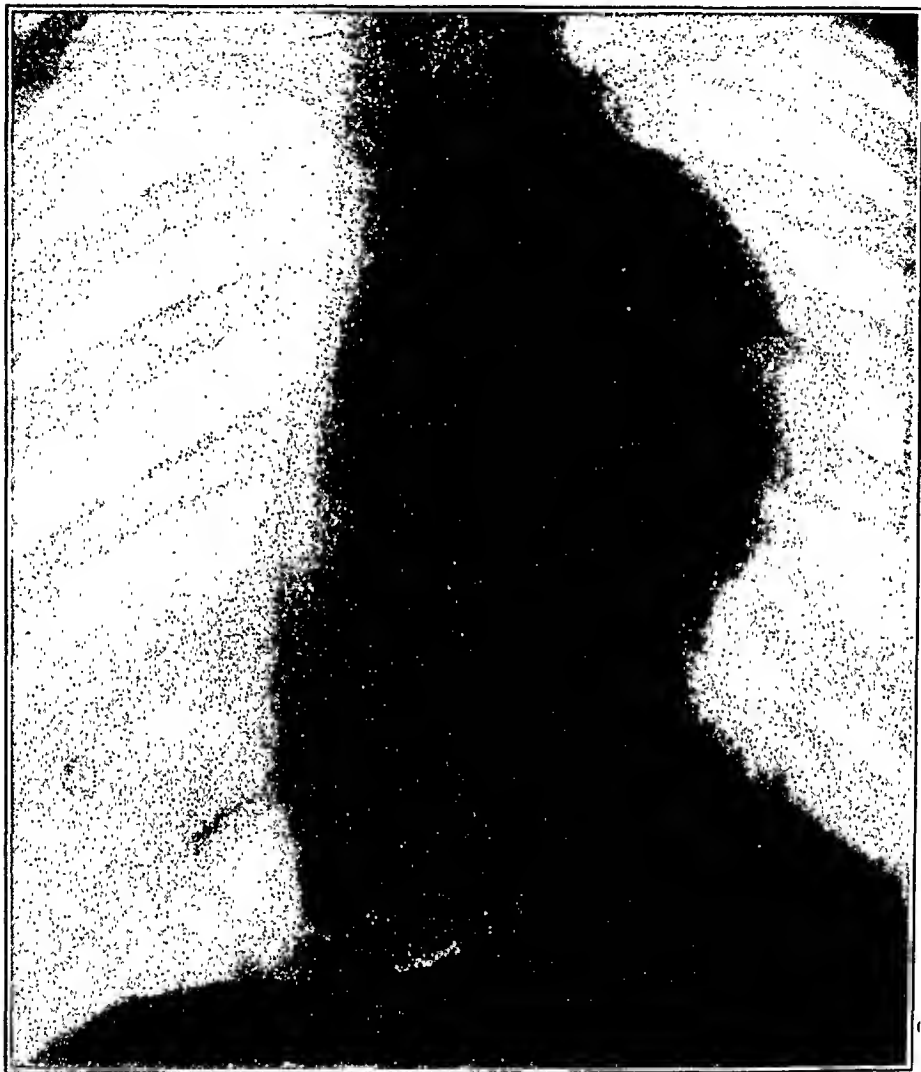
Case III. Plate taken fourteen months after the beginning of treatment. (The first roentgen ray at the time of admission was broken, but the report on it would indicate a shadow of somewhat the same type as the above.)
